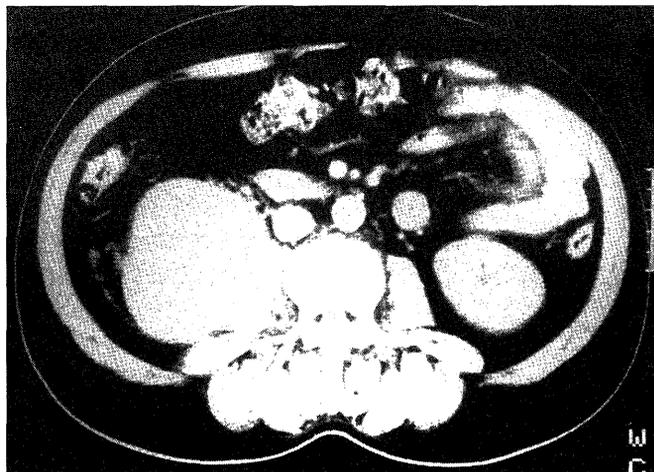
Computed tomographic scan of the abdomen revealed a low density mass that compressed the right psoas muscle.
